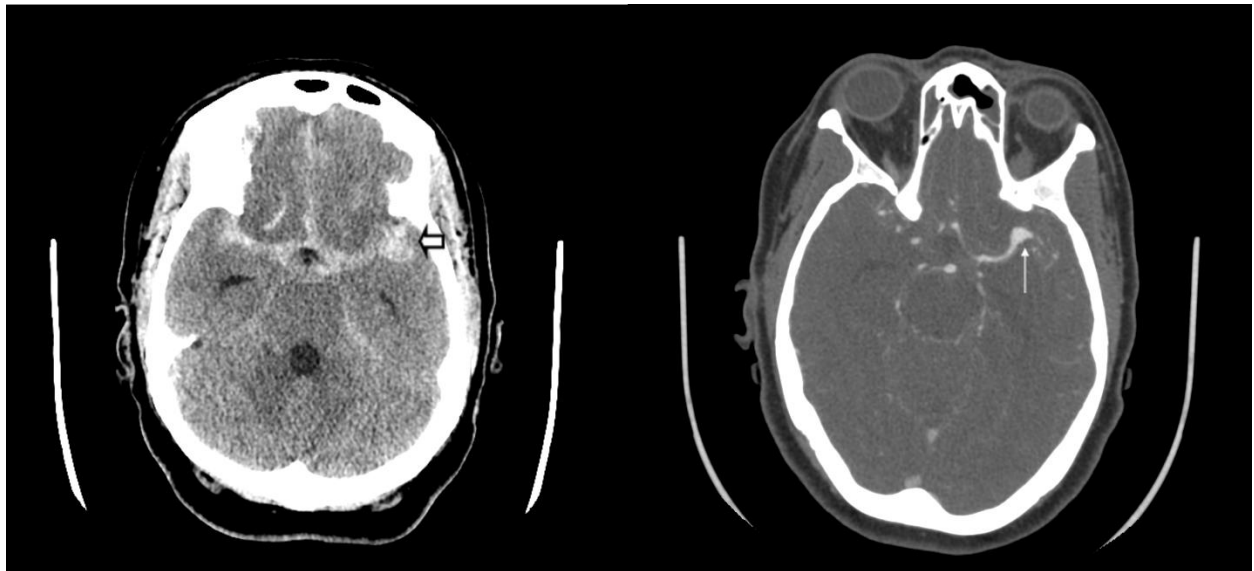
Initial Head CT without contrast demonstrates diffuse subarachnoid hemorrhage in the basilar cisterns with mild asymmetry in the left sylvian fissure (short arrow). A ruptured aneurysm is identified on a subsequent CTA head image at the left MCA bifurcation (long thin arrow).
